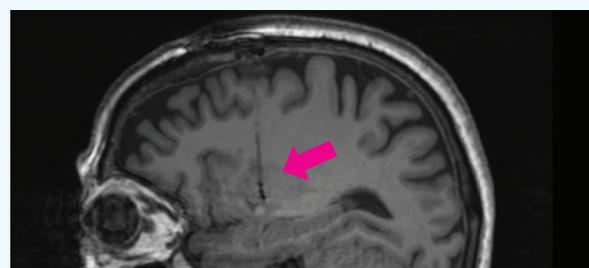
Sagittal MRI showing the cannula tract. Implanted NTCELL microcapsules can be seen distributed through the putamen at the end of the tract.
